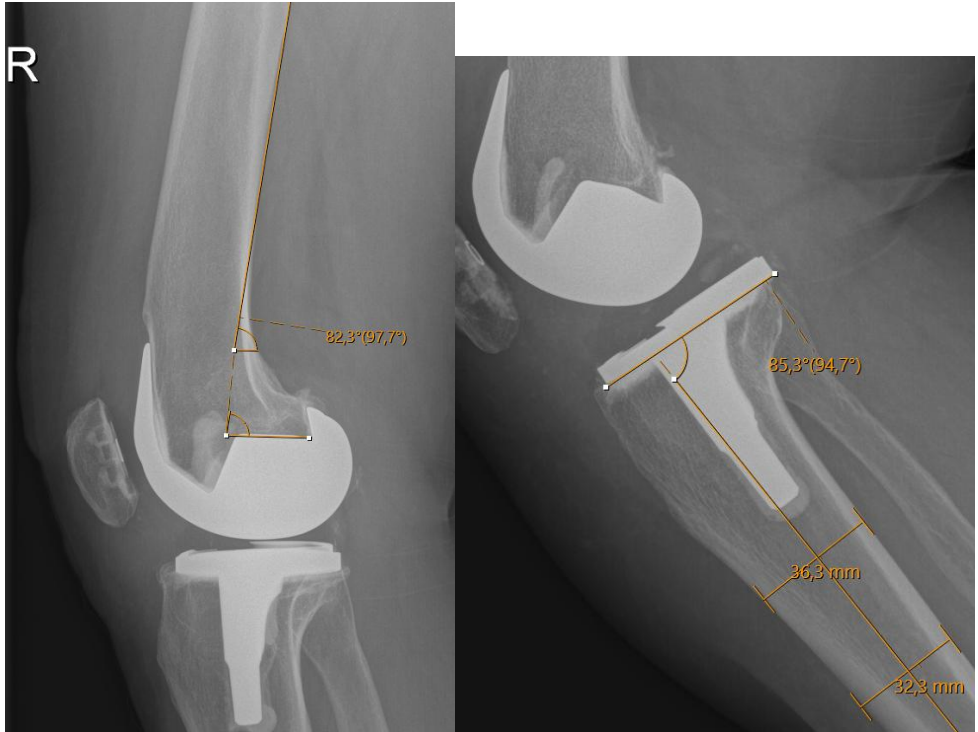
Sagittal radiographic view with measurements of femoral component flexion. The horizontal line is drawn on top of the box which is 90° on the component longitudinal axis.
